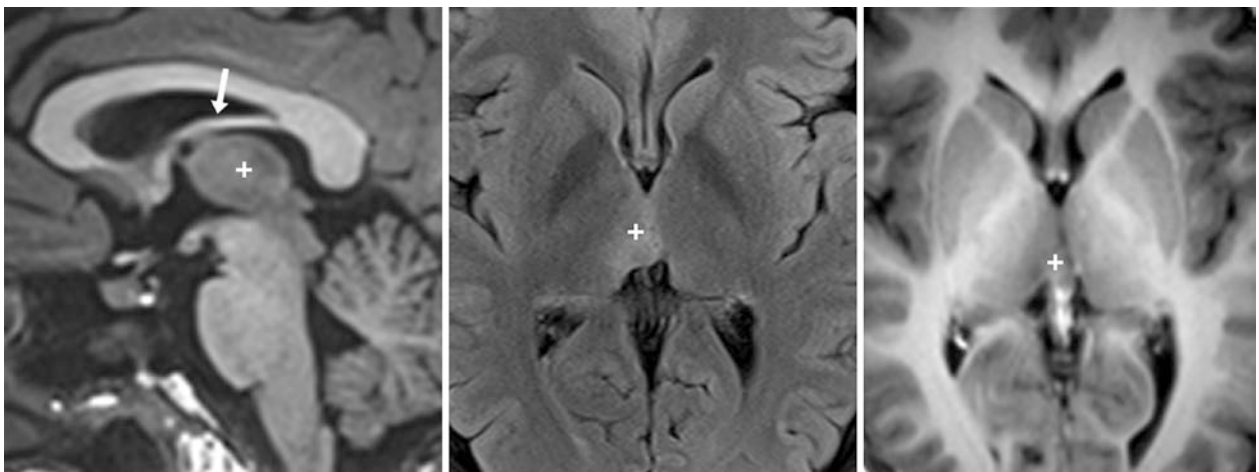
Comparison case of low-grade glioma. An 18 year old with a 3T MRI that depicts a mass involving the massa intermedia (+) on a midline sagittal T1WI (left). Axial FLAIR (middle) and a postcontrast T1WI (right) confirm a mass in that region. Note the body of the fornix superiorly (thick arrow). A biopsy found a low-grade astrocytoma
